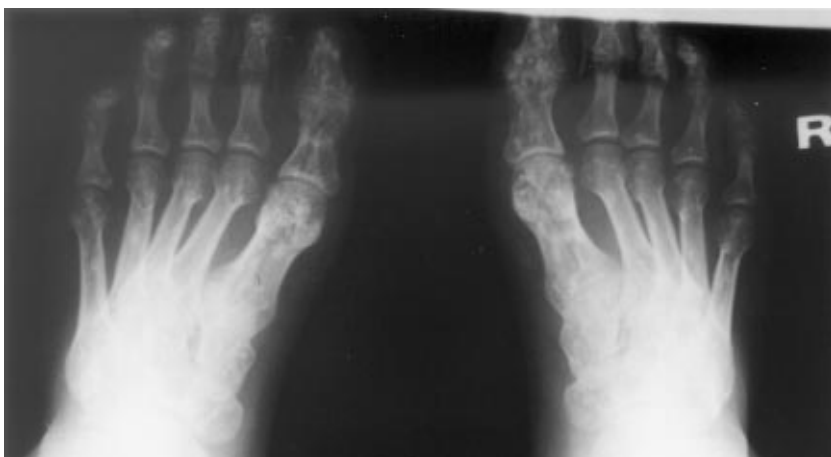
Osteopoikilotic lesions on feet roentgenogram of the patient's mother.
